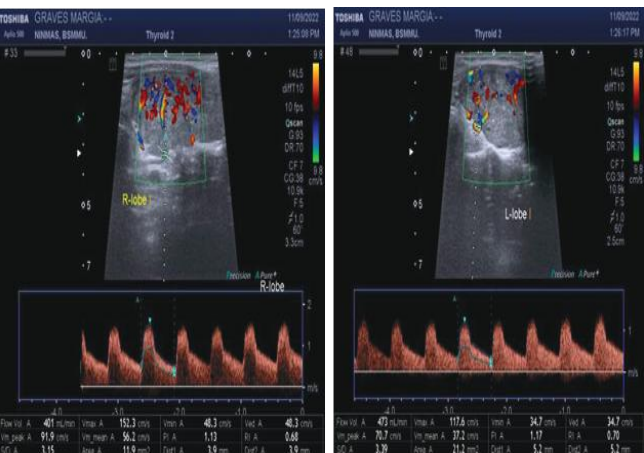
Quantitative Doppler analysis of the superior thyroid artery (STA) revealed that both peak systolic velocity (PSV) and blood flow volume (BFV).
